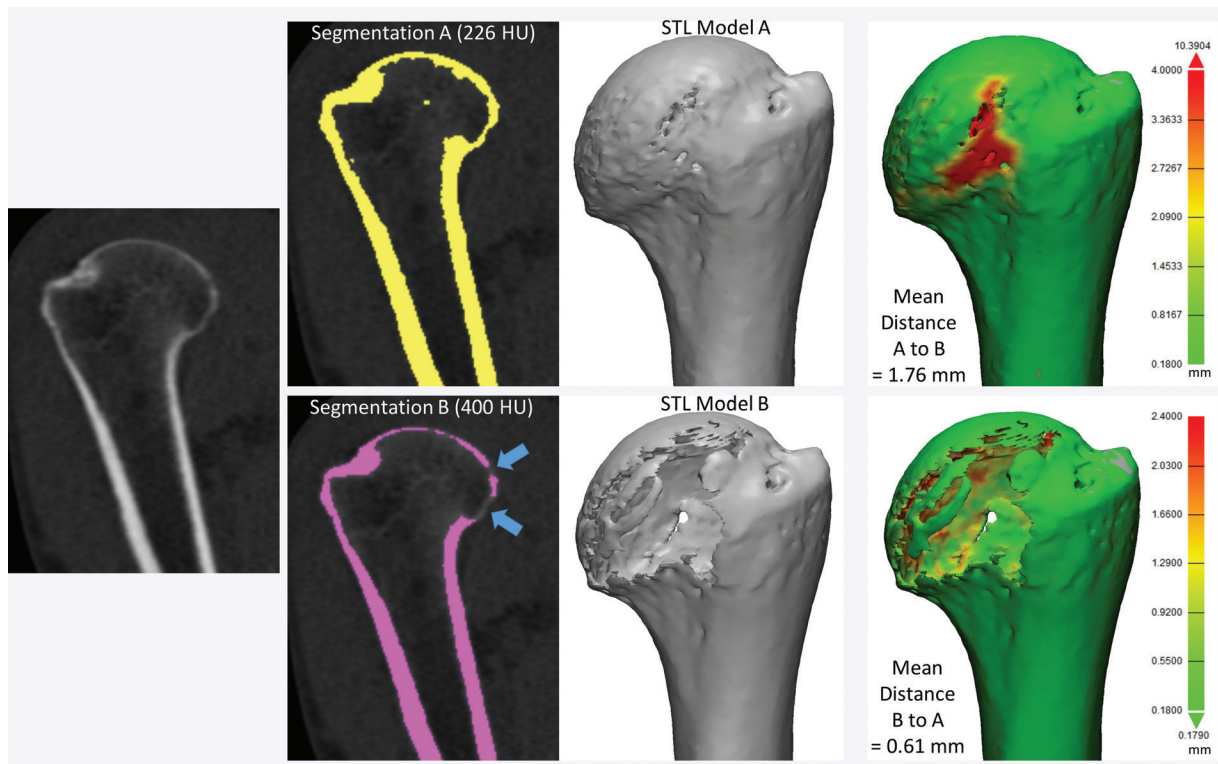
Humerus segmented from a CT image by using attenuation thresholds of 226 and 400 HU. The two resultant 3D models differ in shape, as the model segmented with the higher threshold is missing portions of the humeral head (blue arrows). Distance metrics (green models, far right) did not enable quantification of the difference between the two models; different average, minimal, and maximal distances were measured, depending on which model was being compared with another model.
